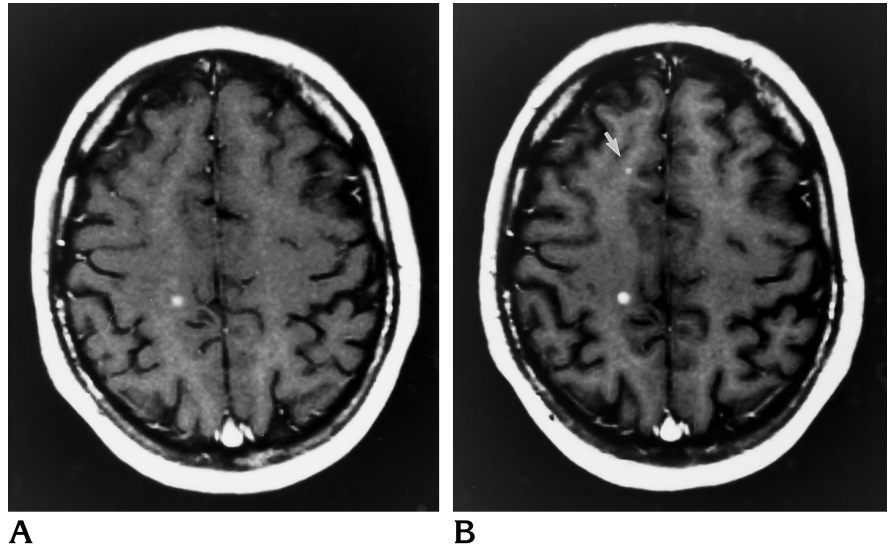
Single-dose MTC contrast-enhanced T1-weighted (500/15/2) image (A) versus triple-dose contrast-enhanced T1-weighted (500/15/2) image (B), both obtained 5 minutes after gadolinium administration. On the triple-dose gadolinium image an additional enhancing lesion is visible in the right frontal lobe (arrow) compared with the single-dose MTC image. The contrast ratio of the enhancing lesion visible on both images increased from 1.30 to 1.50 by using triple-dose gadolinium instead of single-dose MTC. The size of the enhancing lesion increased from 8 to 11 mm².
